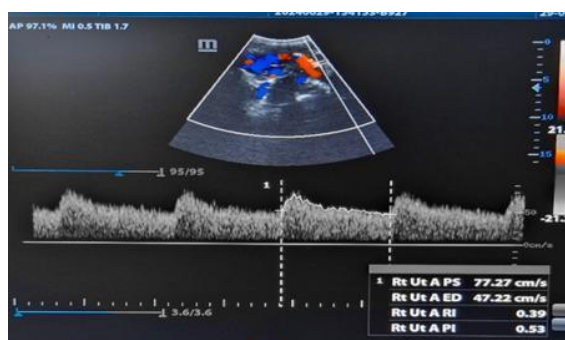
Normal Uterine Artery Doppler In 3rd Trimester
